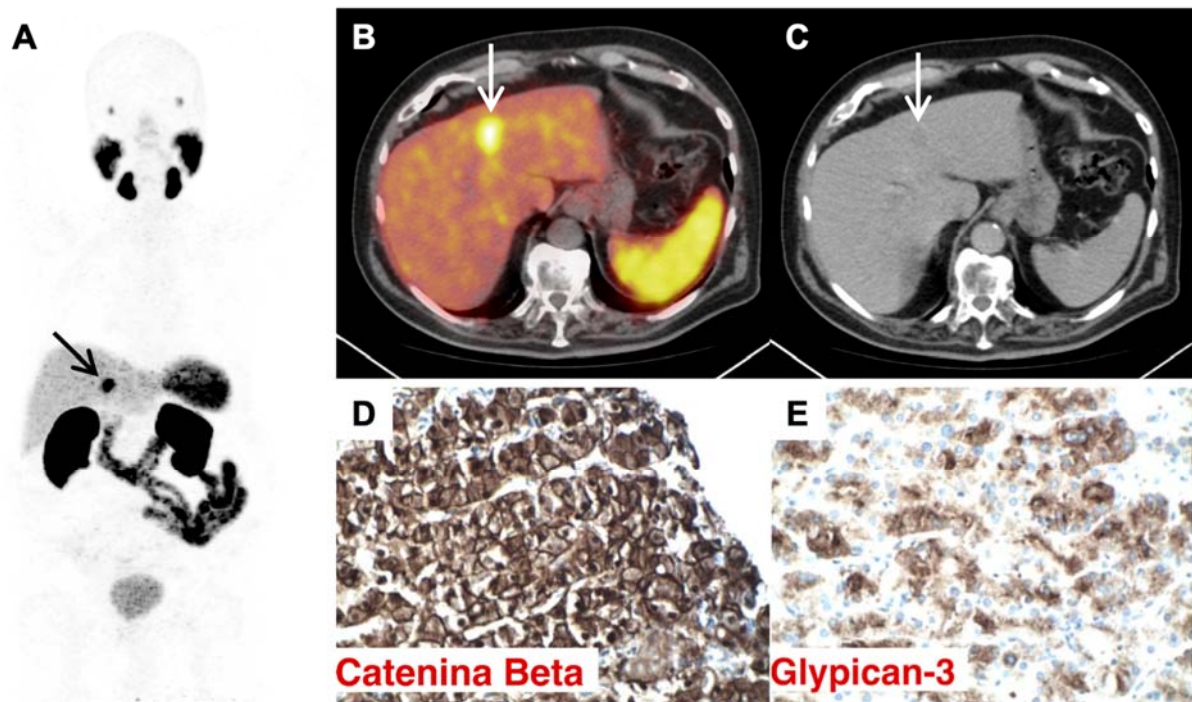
Case example of false positive PSMA-PET for liver metastases.
